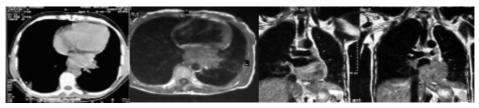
Combined CT and MRI images of Tu invasion of pericardial and mediastinal fat infiltration. Слика 5 – KT и MPИ снимки од Ту инвазија на џерикардоџ и медијасџиналнаџа масџ
